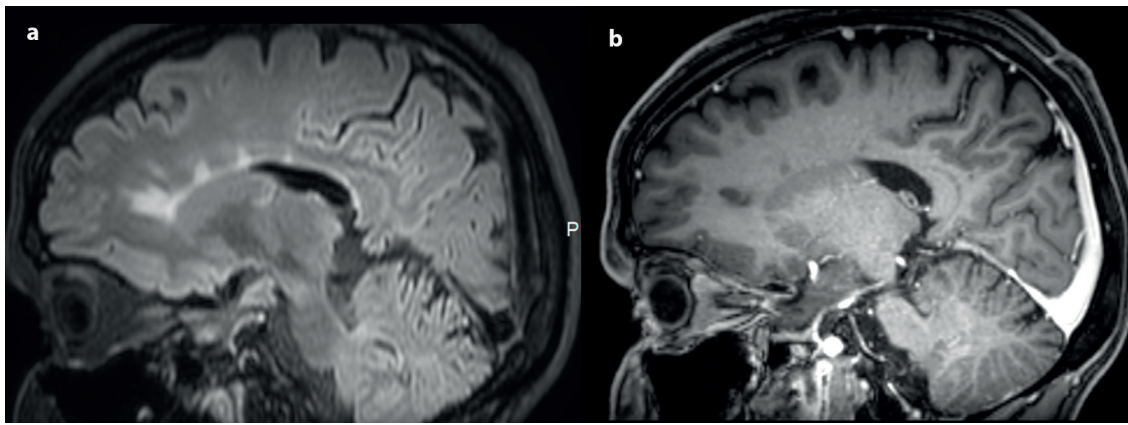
a, b. Sagittal FLAIR (a) and T1-weighted (b) images from the same plane in 28-year-old man with multiple sclerosis. Note that some T2 lesions does not correspond to the black hole lesions on T1-weighted image ('only T2 lesions').
